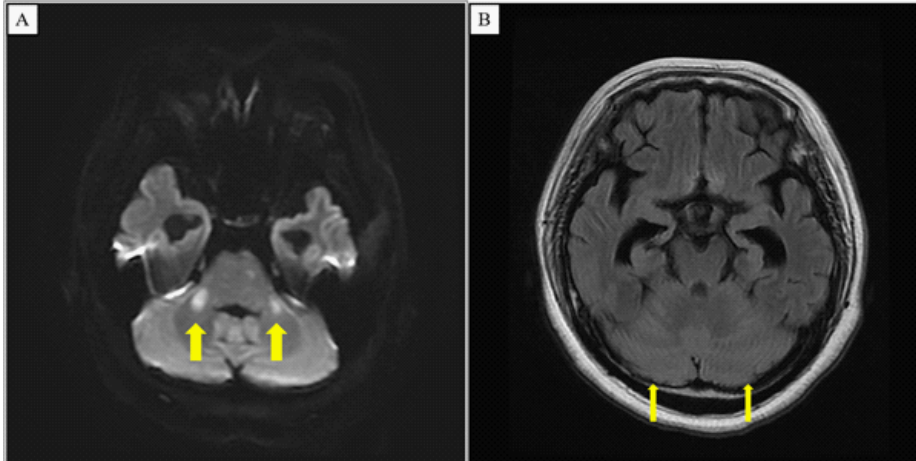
(A) Diffusion-weighted Magnetic Resonance Imaging (MRI) of the head shows high-signal areas in the middle cerebellar peduncles (yellow arrows). (B) On the fluid-Attenuated Inversion Recovery (FLAIR) sequence of the head MRI, a disappearance of the cerebral sulci is observed (small yellow arrows).
